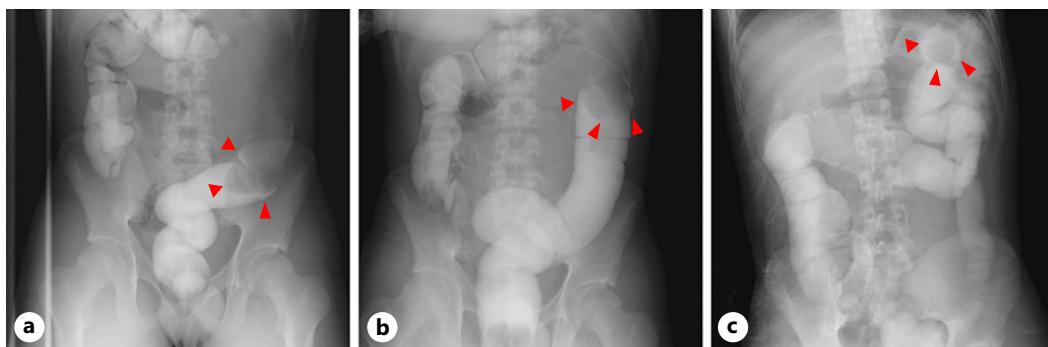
Plain radiography images. a Before the therapeutic enema, a defect was found in the left colon (red arrows). b, c After the enema, the defect moved to the oral side (red arrows).
